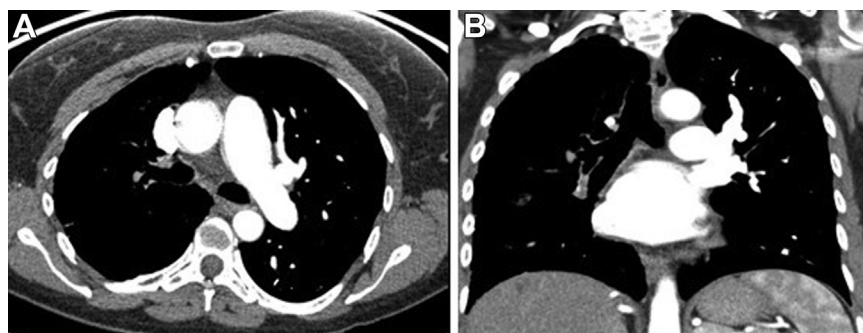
Chest computed tomographic scan; (A) and (B) images reveal the absence of the right pulmonary artery and the absence of the arterial vasculature in the right lung.
